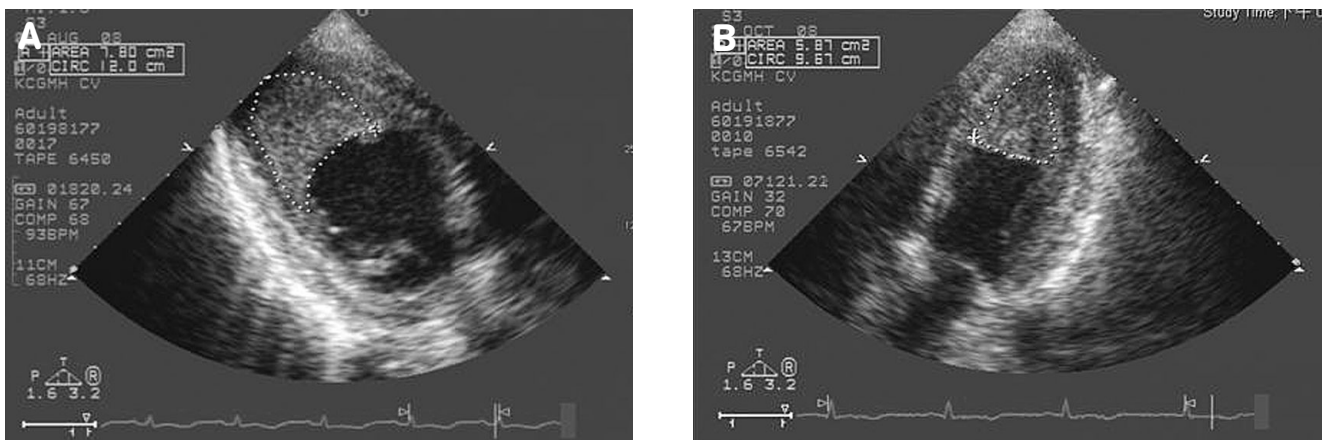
(A) Two-dimensional echocardiogram of the left ventricular (LV) apical two chamber view shows endocardial thickening, reduced size LV cavity, and a large flat LV apical thrombus; (B) Echocardiogram performed two months later shows reduced size of the thrombus.
